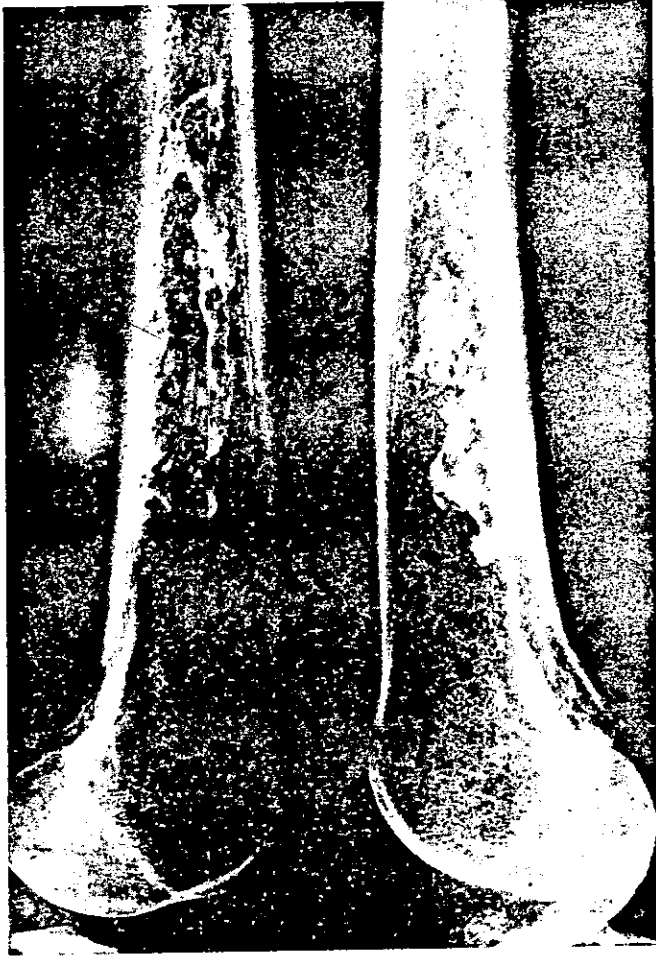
Showing calcification developing in the distal shaft of the left femur over a 7 year period. On the left early calcification is, in fact, present. Again this would be missed on a poor quality radiograph.
